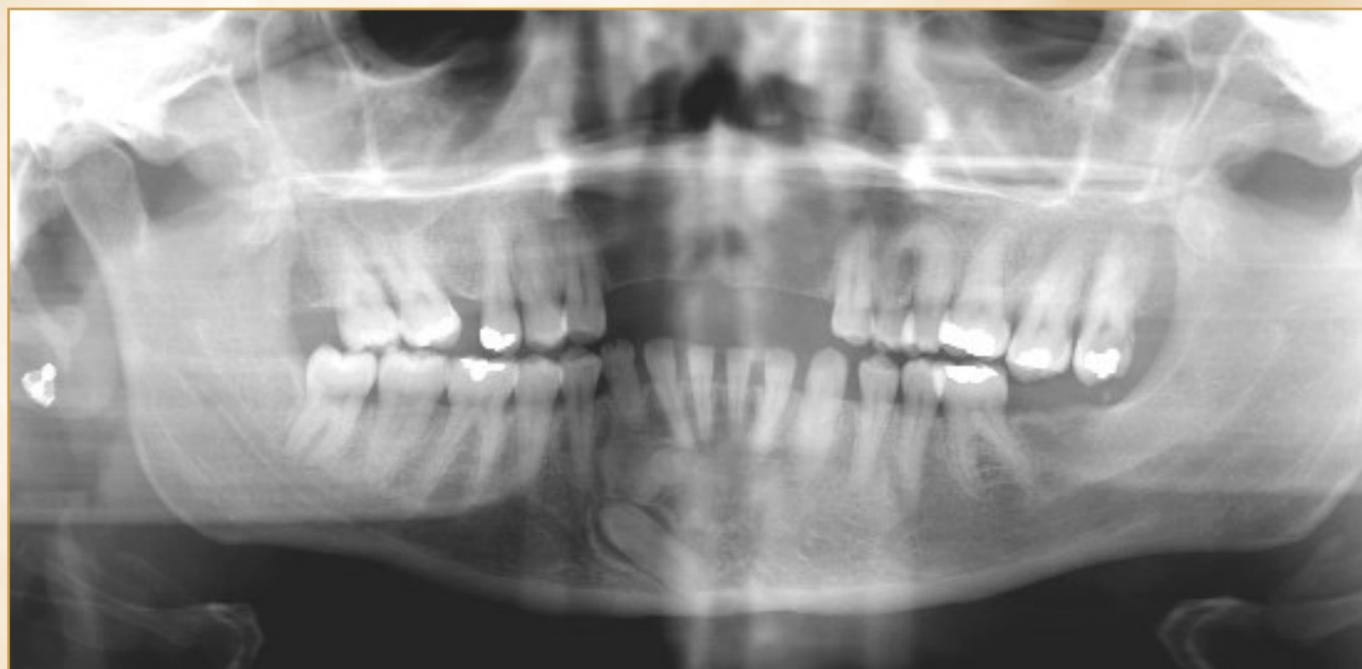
Panoramic radiograph of Case 1 patient.
